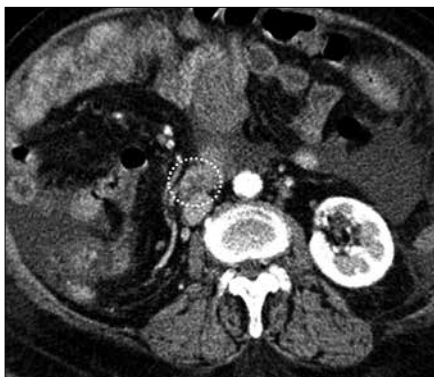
Follow-up axial contrast-enhanced CT scan 3 days after coil-assisted retrograde transvenous obliteration confirmed obliteration of the efferent vein and duodenal varices (dashed circle) in the third portion of the duodenum.
